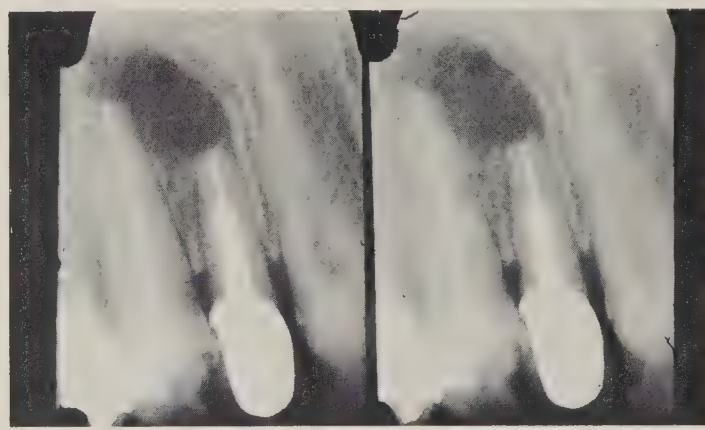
Sequentially reproduced radiographs. These radiographs were taken on the same day
